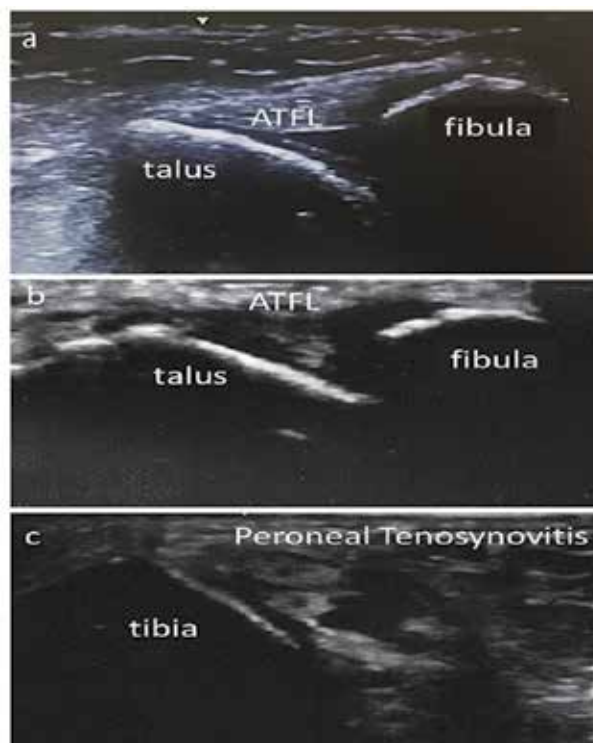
Sonogram of the ATFL. (a) Normal ATFL. (b) Rupture ATFL. (c) Peroneal tendon tenosynovitis.
